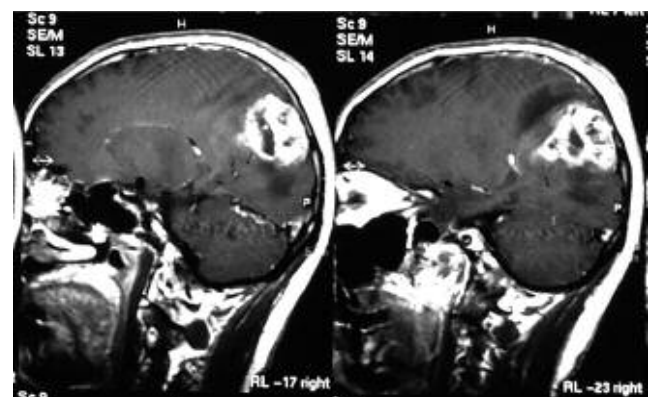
T1-weighted sagittal MRI sequences with gadolinium administration showing the tumor before surgery.
